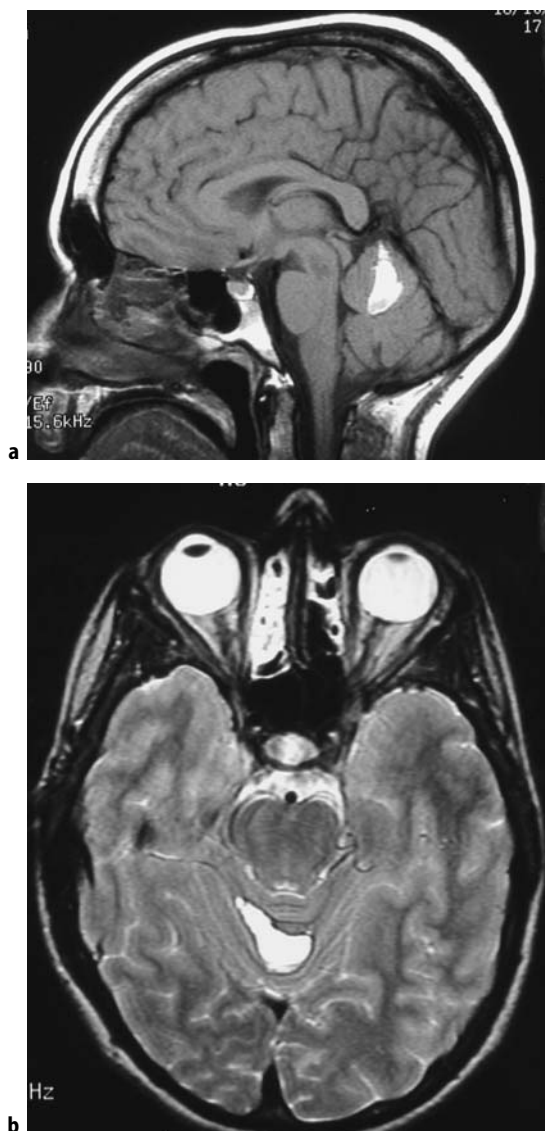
a–b Severe headaches 2 weeks previously, with cerebellar signs. Subacute hematoma is shown with high signal on the T1- and T2-weighted images. a Sagittal T1. b Transverse T2.
